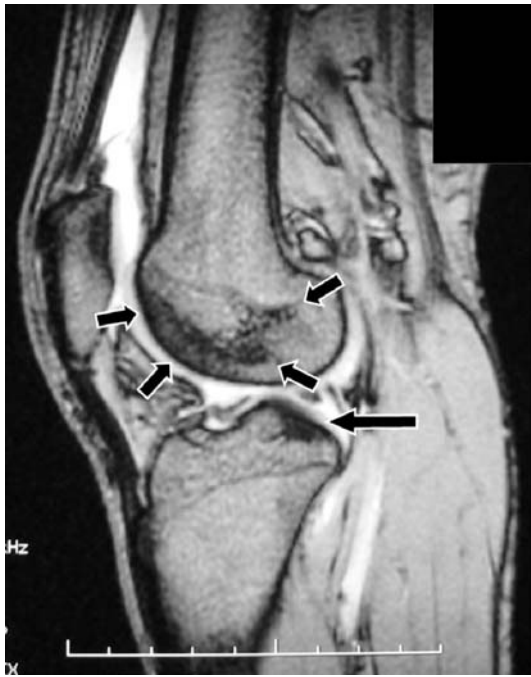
Sagittal T1-weighted magnetic resonance images of the patient's right knee taken on April 28, 2001, showed an irregular low-intensity area in the distal femur and a partial low-intensity lesion in the lateral tibia plateau (arrows) with a small amount of synovial fluid
